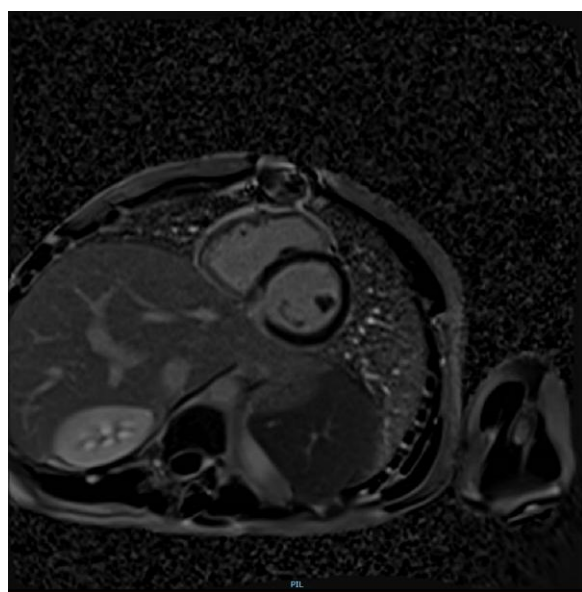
Cardio-MRI. Late gadolinium enhancement imaging reveals late transmural enhancement in the inferobasal region, indicative of an evolved infarction in a small area of the right coronary artery (RCA) territory.
